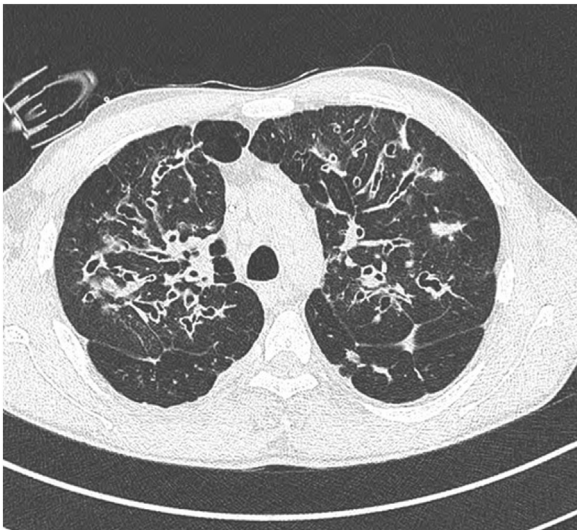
Recipient's chest CT scan pre-transplantation.
